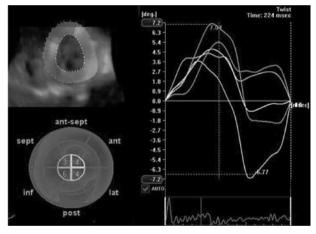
Apical twist values detected by color coded 3-dimensional speckle tracking echocardiography from apical 1 short-axis level of LV (top left) and bullseye plot image (bottom left) and corresponding time-to-strain curves from apical segment sites (right)
